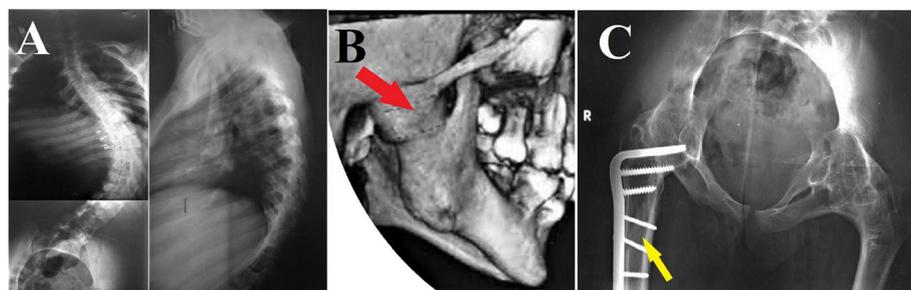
Serial imaging studies performed in the emergency department. a Plan radiograph of the spine showing kyphoscoliosis deformity. b Skull CT showing fusion of the temporomandibular joint (red arrowhead). c Right femur subtrochanteric fracture fixed with a plate (fracture line indicated by the yellow arrowhead)
